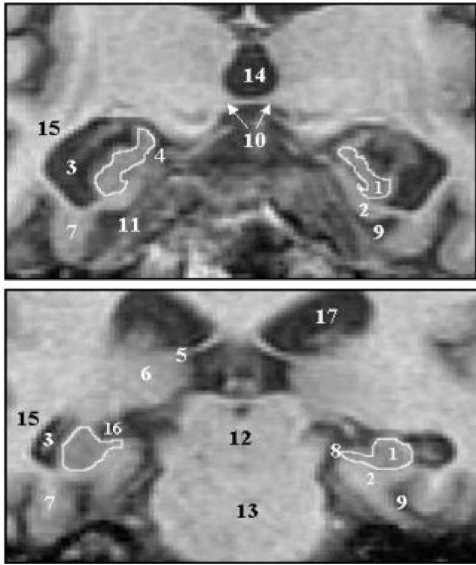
Magnified coronal MRI images of anterior (upper image) and posterior (lower image) hippocampal slices of a 67-year-old male patient with MCI who subsequently converted to Alzheimer disease. The anterior slice is at the level of the hippocampal-amygdalar transitional area, and the posterior slice is at the level where the pulvinar surrounds the crus of the fornix. 1 = Hippocampus; 2 = parahippocampal gyrus; 3 = temporal horn of lateral ventricle; 4 = uncus; 5 = crus of fornix; 6 = pulvinar; 7 = fusiform gyrus; 8 = ambient cistern; 9 = collateral sulcus; 10 = mammillary body; 11 = tentorium cerebelli; 12 = cerebral aqueduct; 13 = pons; 14 = third ventricle; 15 = temporal stem; 16 = transverse fissure; 17 = lateral ventricle.
